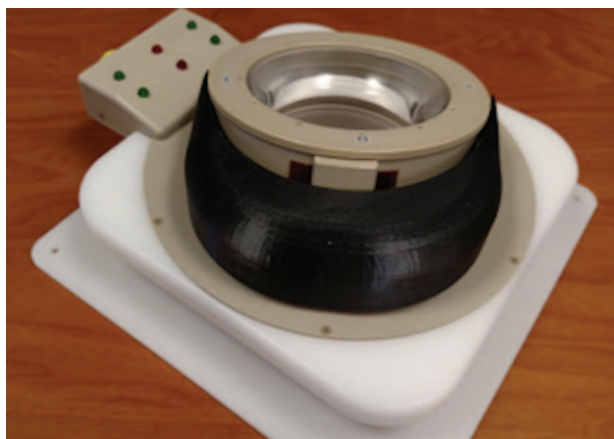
Body-mounted robot for MRI-guided cryoablation of abdominal organs.¹⁹
